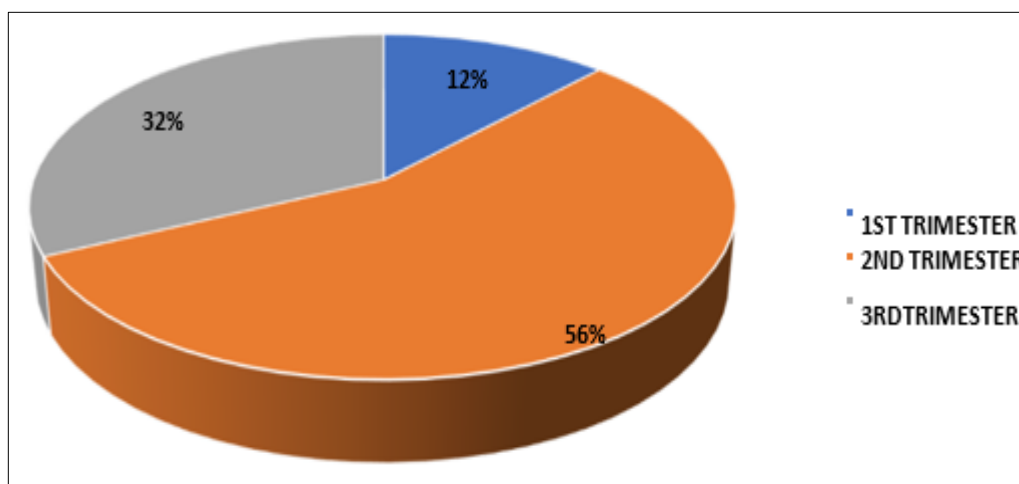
Distribution of MRI Scans According to Trimester of Pregnancy
